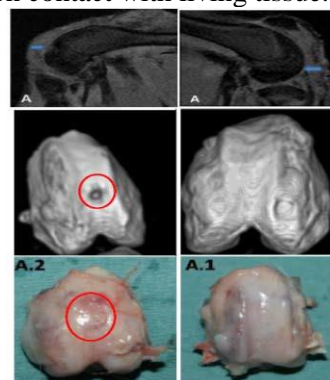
Images of NMR, 3D CT and macroscopic observation (top, medium and bottom row respectively) of left knees treated with ELR hydrogel (left column) and right knees treated with hydrogel with hMSCs (right column).
